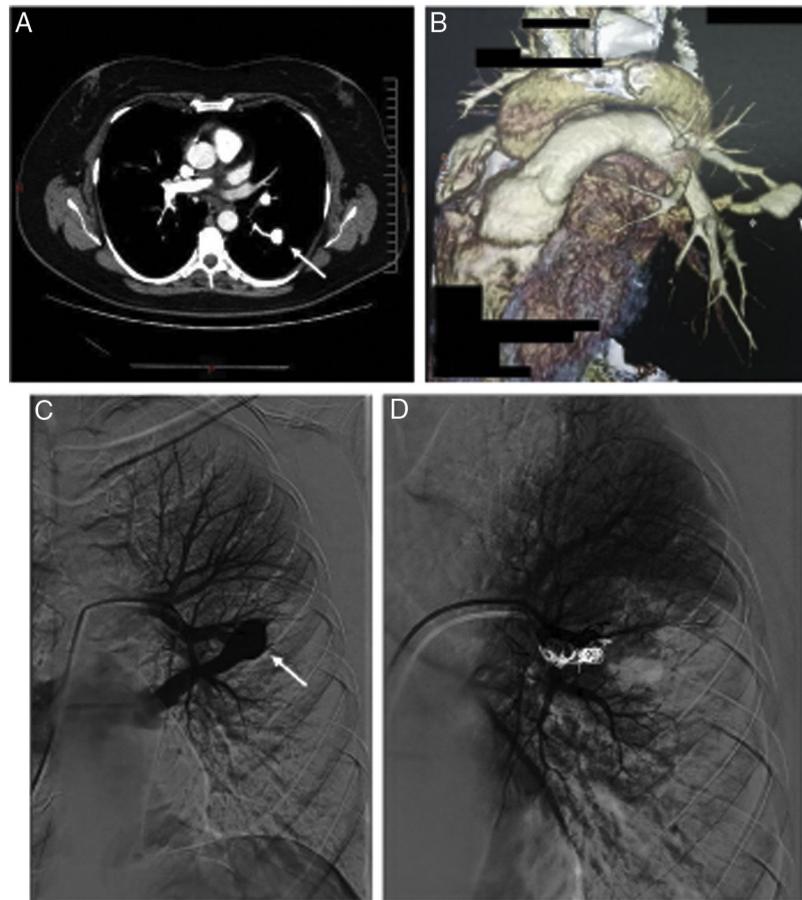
Thoracic CT scan and angiogram images of the pulmonary arteriovenous malformation. (A) The axial thoracic CT image (mediastinal window) shows an aneurysmal sac (arrow), with a connection to a sub-segmental branch of the upper branch of the pulmonary artery. (B) 3D-volume rendering CT image that shows an aneurysmal sac with a connection to a sub-segmental branch of the upper branch of the pulmonary artery, and at the lower end to a pulmonary vein (*). (C) Selective left pulmonary artery branch angiogram showing the pulmonary arteriovenous malformation (arrow). (D) Postembolization pulmonary arteriogram with complete occlusion of the pulmonary arteriovenous malformation.
